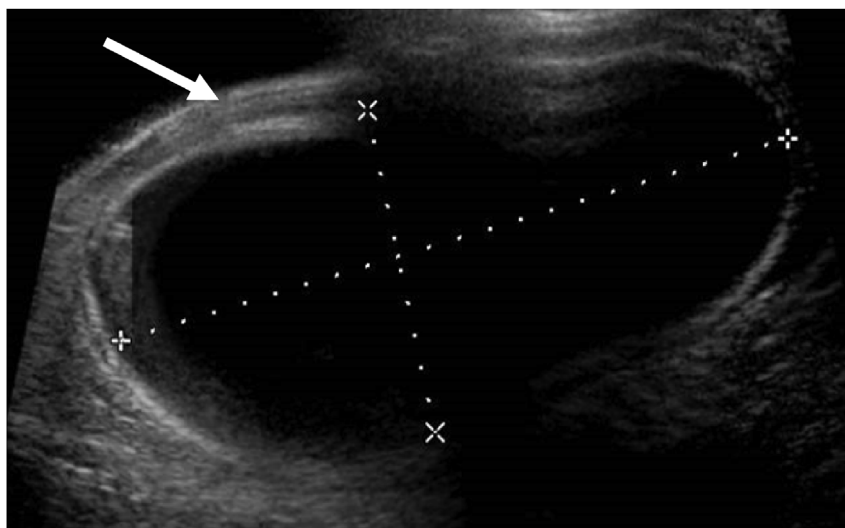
Ultrasonography showing a double-layered wall (arrow) characteristic of duplication cysts.
